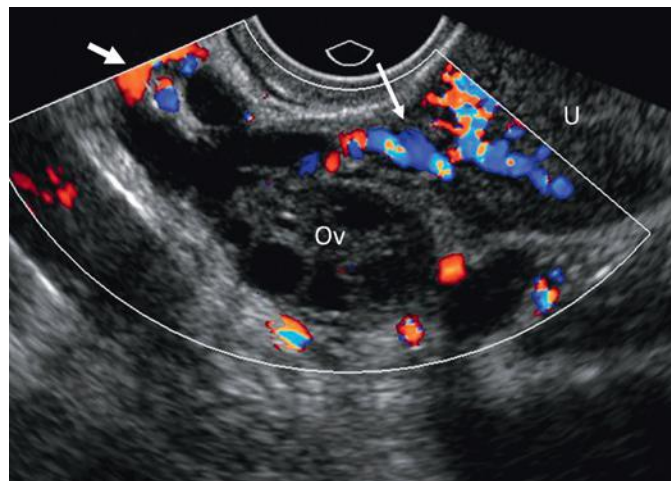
Suspensory ligament and ovarian artery. Oblique longitudinal transvaginal sonogram of the left adnexa showing the ovarian artery (*short arrow*), which lies within the laterally and superiorly located suspensory ligament, and the ovarian branches of the uterine artery (*long arrow*), which lie medially in the broad ligament. Ov, ovary; U, uterus.
